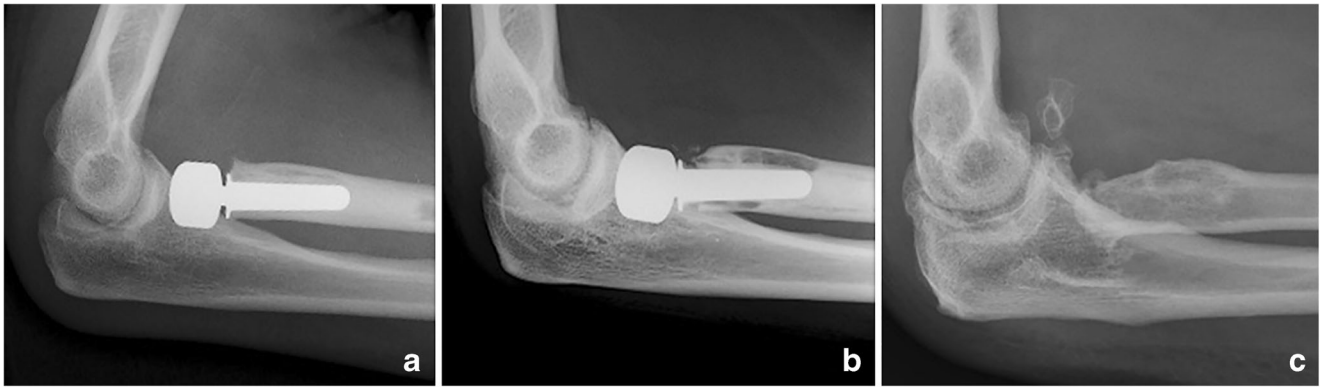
Three sequential lateral radiographs of the elbow showing progressive loosening of a radial head prosthesis (Guepar[®], Aston Medical, Saint Etienne, France), at follow up intervals of 0.7 and 1.6 years (a, b respectively). The implant had to be removed two years after the initial arthroplasty (c)
